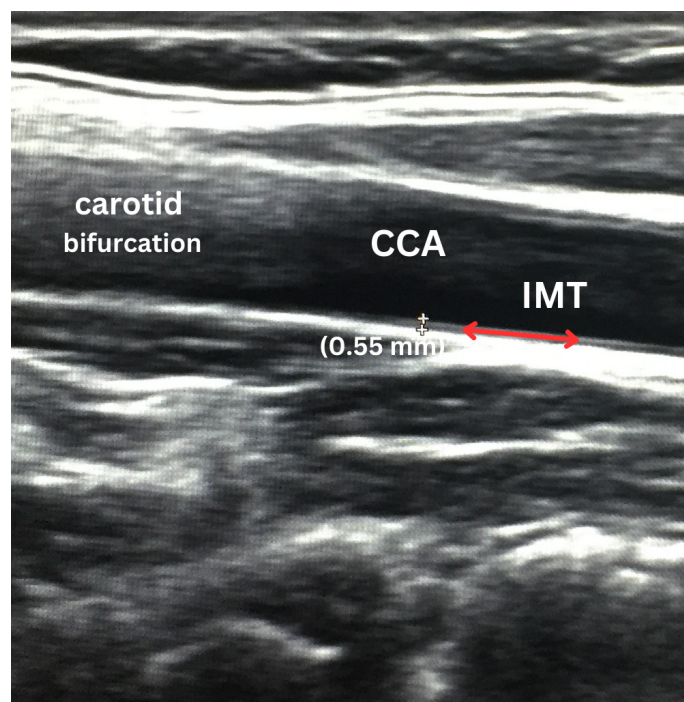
Ultrasonographic measurement of carotid artery intima-media thickness (red line), the space between “(+) – (+)” (CCA: Common carotid artery, IMT: intima-media thickness)
